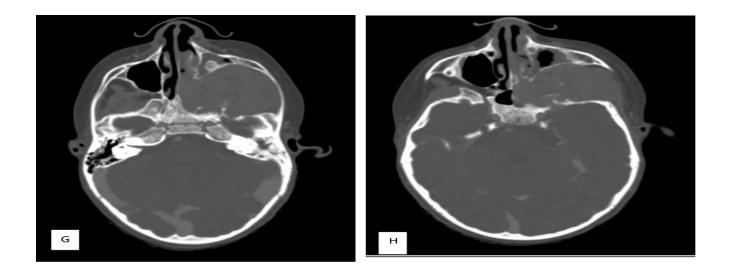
(A-E) Axial and oronal and cut of contrast-enhanced CT scan of the neck and head, and (F-H) bonereconstruction CT. Computed tomography (CT) neck and head with contrast demonstrated a poorly enhancing expansile mass in the left infratemporal fossa region(ITF) with areas of necrosis within. The tumor was seen to extend to the left sphenoid sinus (Fig.D)., left ethmoid sinus, nasal cavity (Fig.A)., left parapharyngeal space, left pterygopalatine fossa (Fig.A). and left orbital cavity (Fig.B). There was also destruction of skull base (Fig.G) and extension to the left foramen ovale (Fig.A)., left cavernous sinus and left temporal lobe (Fig.E). The mass appeared to have caused some bony erosion of the posterior aspect of the left maxilla (Fig.H). The left maxillary antrum was reduced in volume (Fig.C). It thins the left mandibular ramus and the left zygomatic process (Fig.F).without cortical lysis and extends to the soft tissue of the cheek. The lateral pterygoid process was expanded, the median pterygoid process was eroded (Fig.F).
